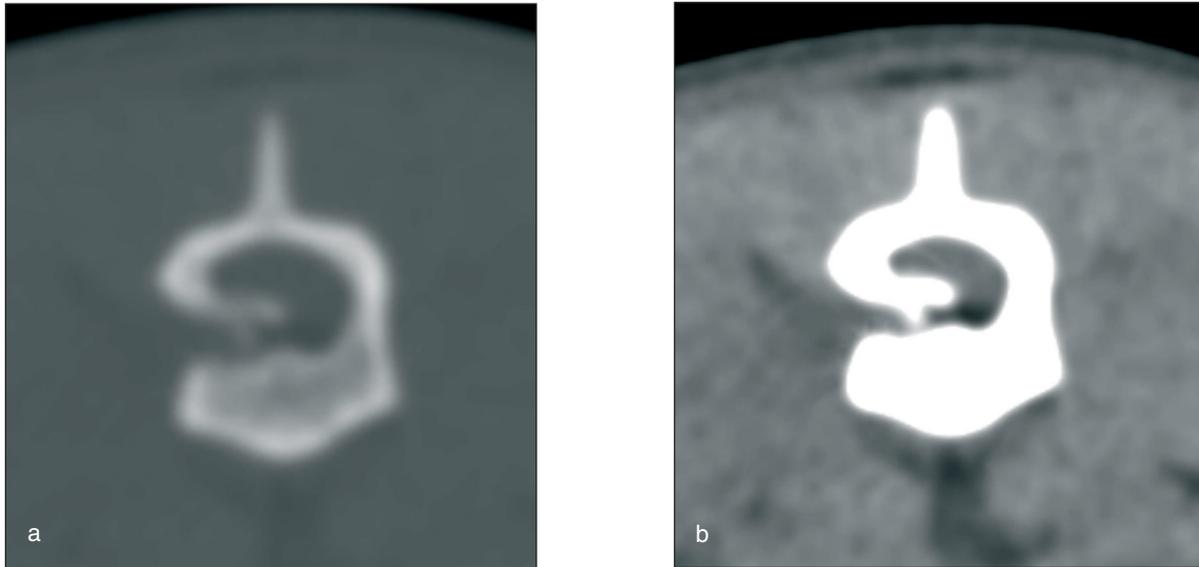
Transverse single slice CT images of the first lumbar vertebra in a bony (a) and soft tissue (b) window; the left vertebral arch reveals an impression fracture with a nearly lamellar bony fragment being dislocated into the vertebral canal. The bone dislocates and compresses the spinal cord dorsally and to the right.
